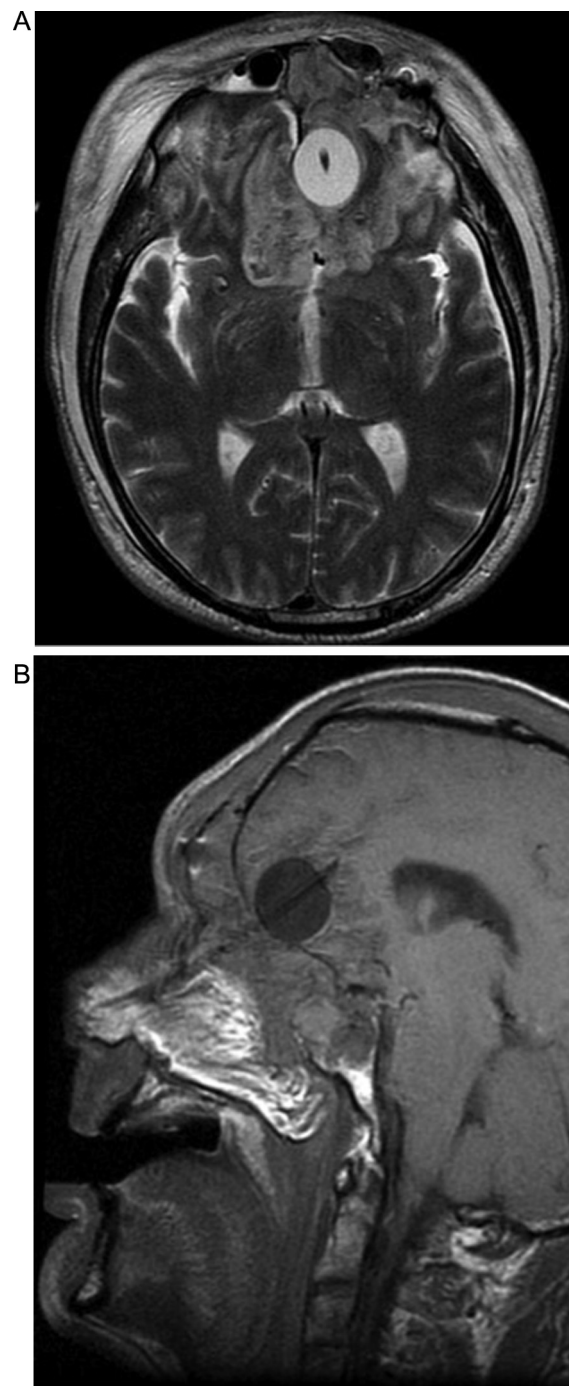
(A) Axial T2-weighted MRI demonstrating Foley catheter balloon in the left frontal lobe with bifrontal contusions and edema. (B) Sagittal T1-weighted MRI demonstrating balloon deployed superior to the skull base defect.
